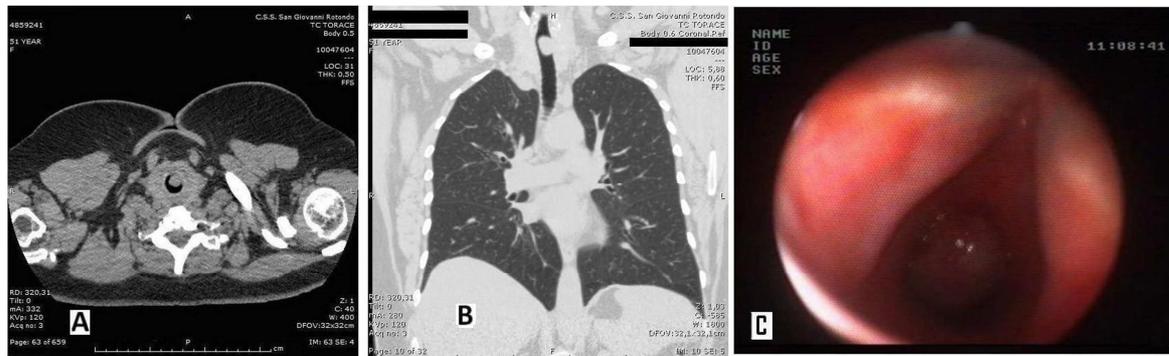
A. Transversal sections of chest and neck computed tomography. B. Frontal section of chest and neck computed tomography. C. Endoscopic view of ETP.
